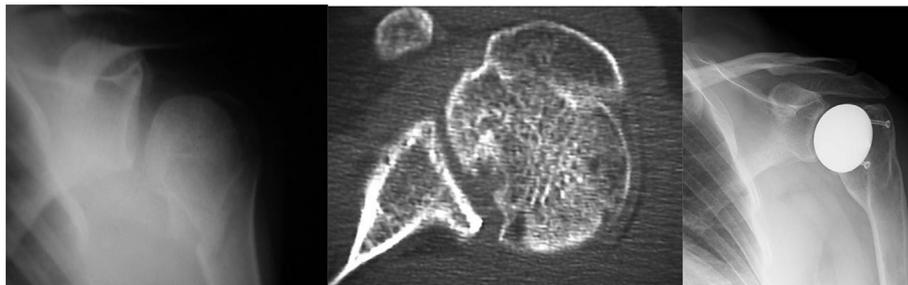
A, 2B and 2C – Pre-operative, post-operative and 17 year follow-up radiographs of a 26 year old with head splitting proximal humeral fracture dislocation treated successfully with humeral resurfacing and autograft.
